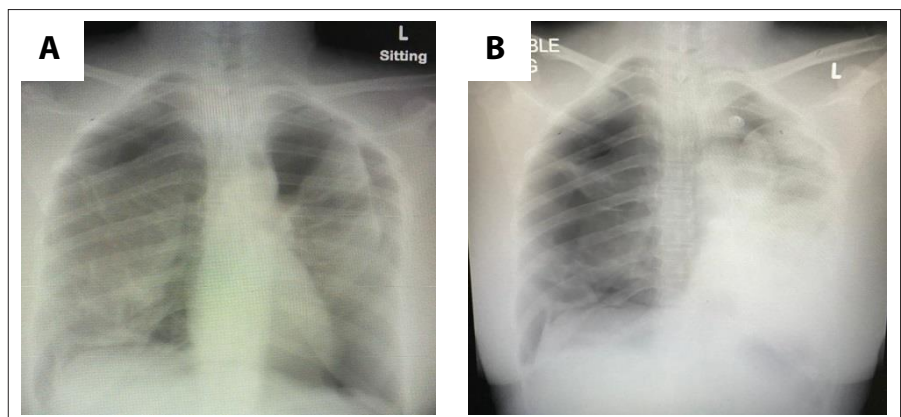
Chest radiographs at first (A) and second (B) presentation.
